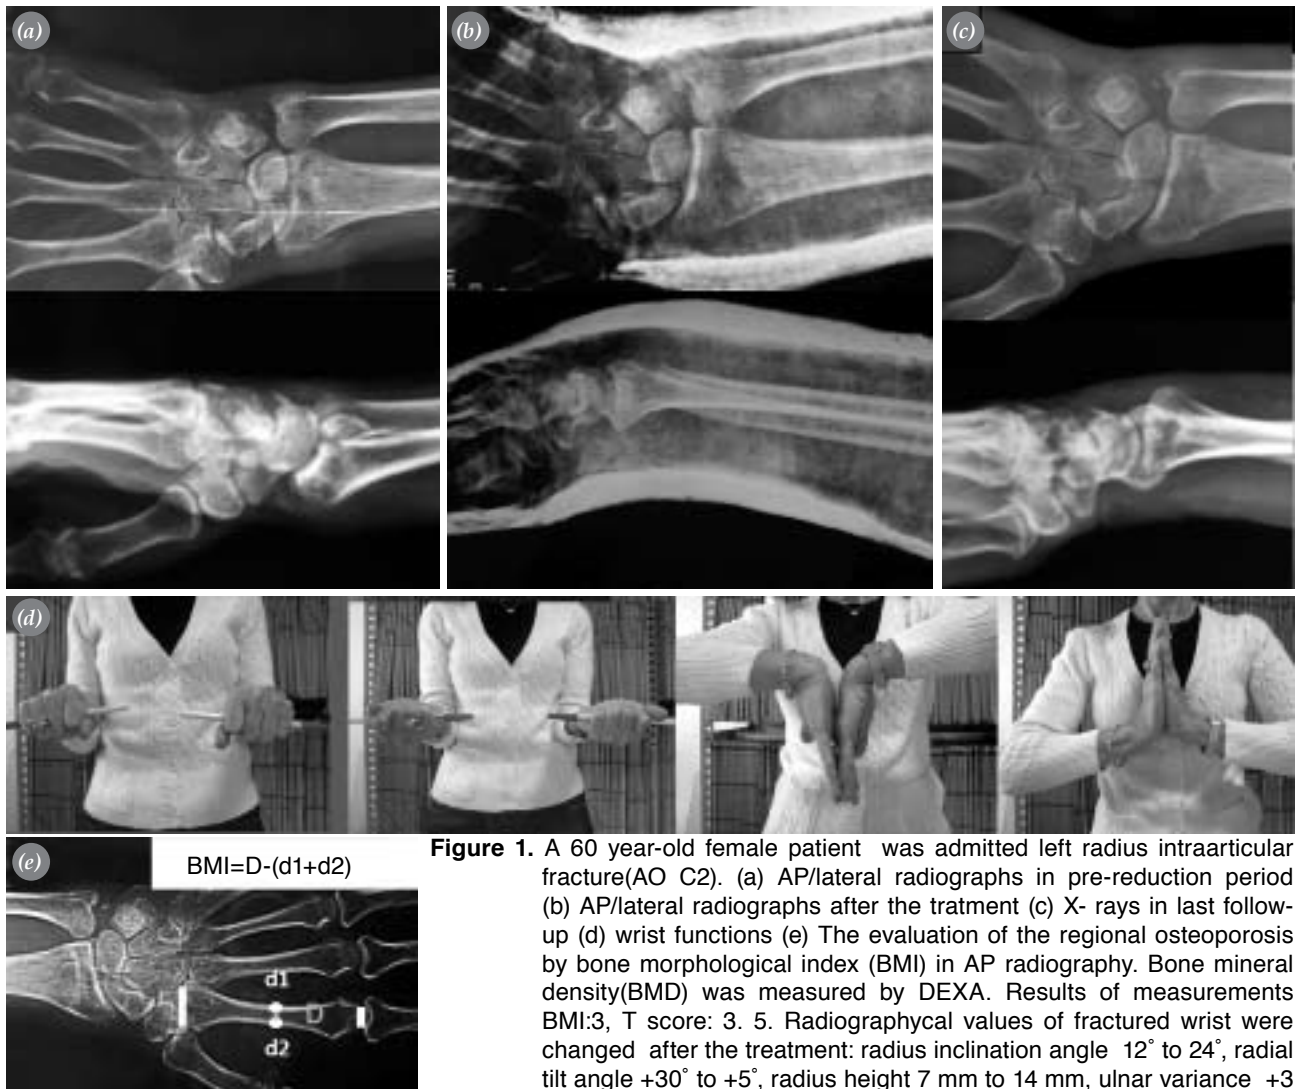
A 60 year-old female patient was admitted left radius intraarticular fracture(AO C2). (a) AP/lateral radiographs in pre-reduction period (b) AP/lateral radiographs after the treatment (c) X- rays in last follow-up (d) wrist functions (e) The evaluation of the regional osteoporosis by bone morphological index (BMI) in AP radiography. Bone mineral density(BMD) was measured by DEXA. Results of measurements BMI:3, T score: 3. 5. Radiographycal values of fractured wrist were changed after the treatment: radius inclination angle 12° to 24°, radial tilt angle +30° to +5°, radius height 7 mm to 14 mm, ulnar variance +3 mm ve neutral. Results of stewart rating scale and DASH scores respectively 3 and 4. 5 points.
